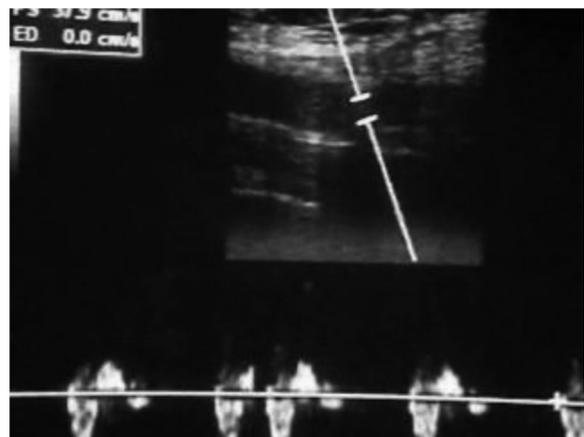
Ultrasound showing normal Doppler signal and normal vessel lumen size above, below, and at the site of implantation. Position of implant indicated by the yellow circle.
